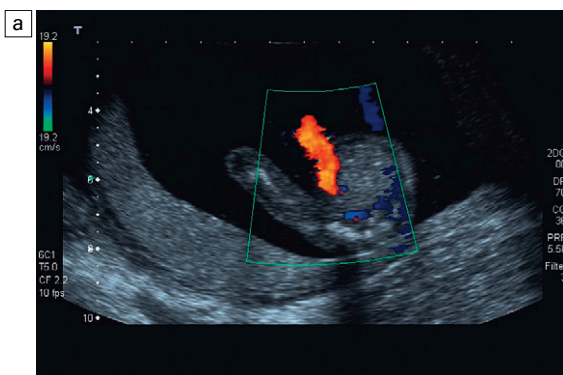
(a) Colour flow Doppler through the pelvis of a fetus with a single umbilical artery. (b) Single umbilical artery in the pelvis flanked by two femoral arteries.
